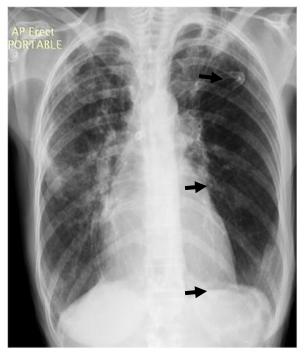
Right lung multilobar opacities seen in a patient with chronic obstructive pulmonary disease, in this indeterminate pattern chest radiograph (43)
